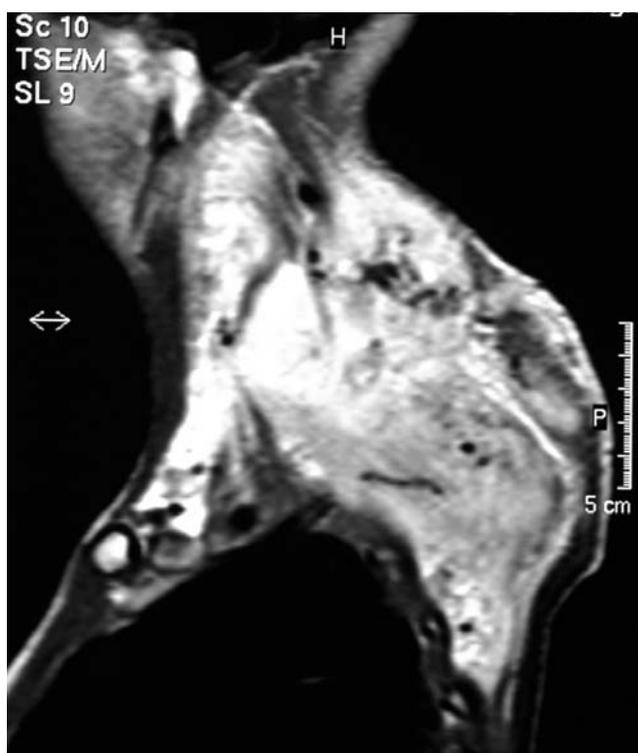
Case 2. A lateral view of the chest MR image shows a large mass of the chest and neck.
